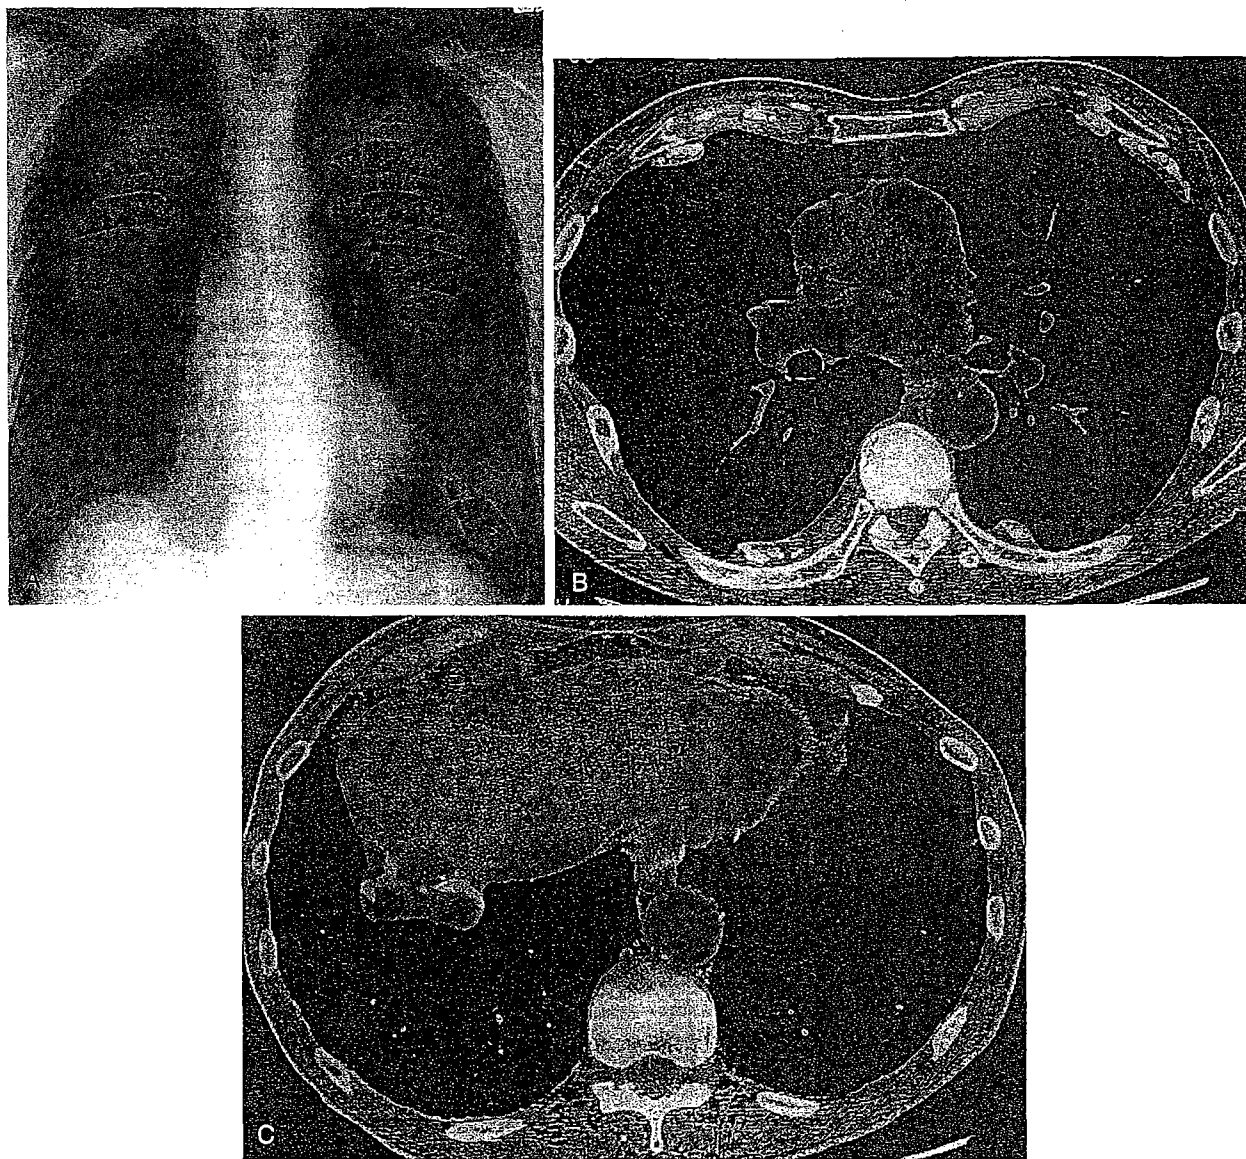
Calcified Pleural Plaques. A posteroanterior chest radiograph (A) in an 82-year-old man demonstrates numerous bilateral calcified pleural plaques. The patient had worked for many years in a shipyard. HRCT (B and C) demonstrates calcified plaques along the posteromedial and anterolateral chest wall and right hemidiaphragm.
